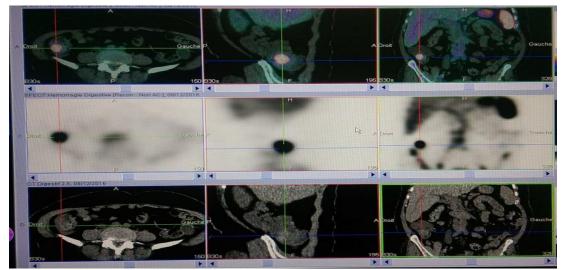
SPECT (middle), CT (bottom) and SPECT/CT fusion images (top), in axial, sagittal and coronal slices, in the same area where the abnormal finding on the pertechnetate scan was found.
